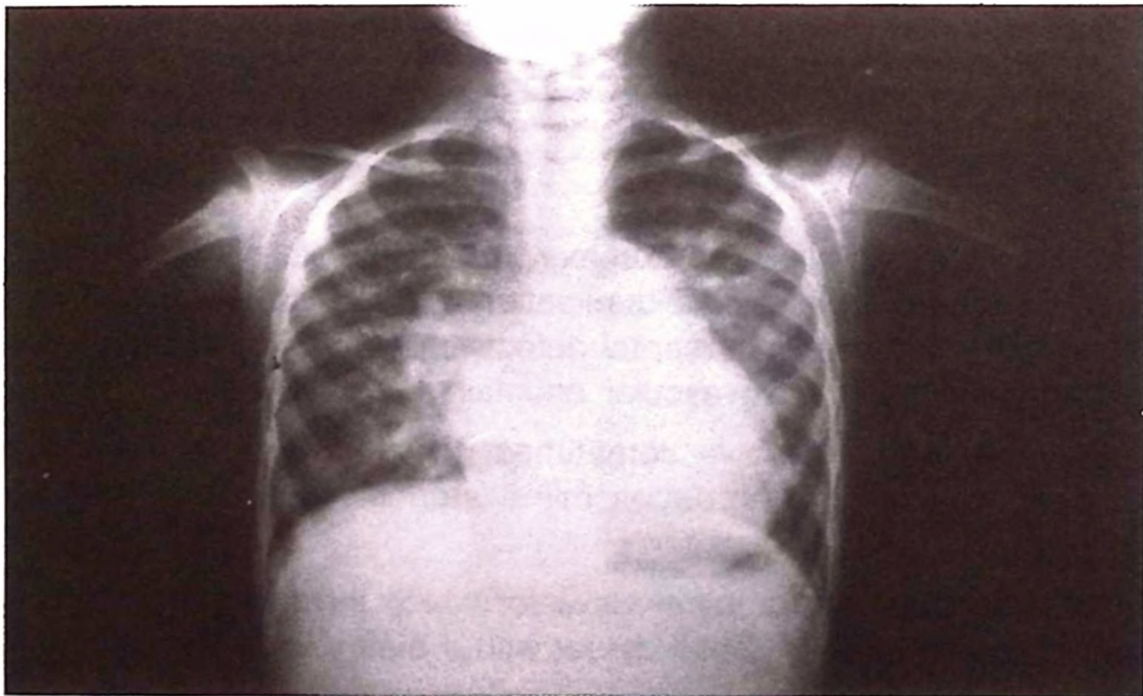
Chest roentgenogram demonstrating cardiomegaly and increased pulmonary vascularity.
